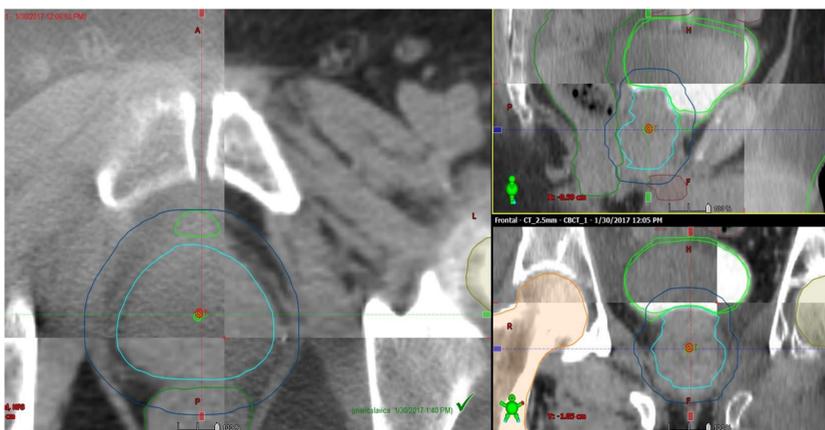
Matching a CBCT with the patients planning CT.
